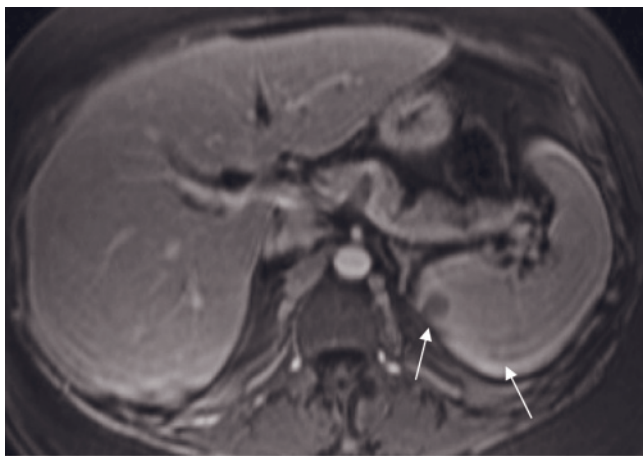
Splenic metastases. T1-weighted SGE (a), T2-weighted fat-suppressed spin-echo (b), and immediate postgadolinium T1-weighted SGE (c) images in a woman with endometrial cancer. Metastases are noted throughout the spleen that are mixed hypointense and isointense on the T1-weighted image (a), mixed isointense and hyperintense on the T2-weighted image (b), and low in signal intensity on the immediate postgadolinium image (c). Note that metastases are best shown on the immediate postgadolinium image. The largest metastasis is distinctly demonstrated on the T2-weighted image (b). The smaller lesions are poorly shown, despite the presence of iron deposition. Ascites is also present and is low in signal intensity on pre- and postcontrast T1-weighted images and high in signal intensity on the T2-weighted image. Transverse 90-s postgadolinium fat-suppressed SGE image (d) in a second patient demonstrates an expansive destructive lesion (arrow, d) in the posterior aspect of the spleen associated
